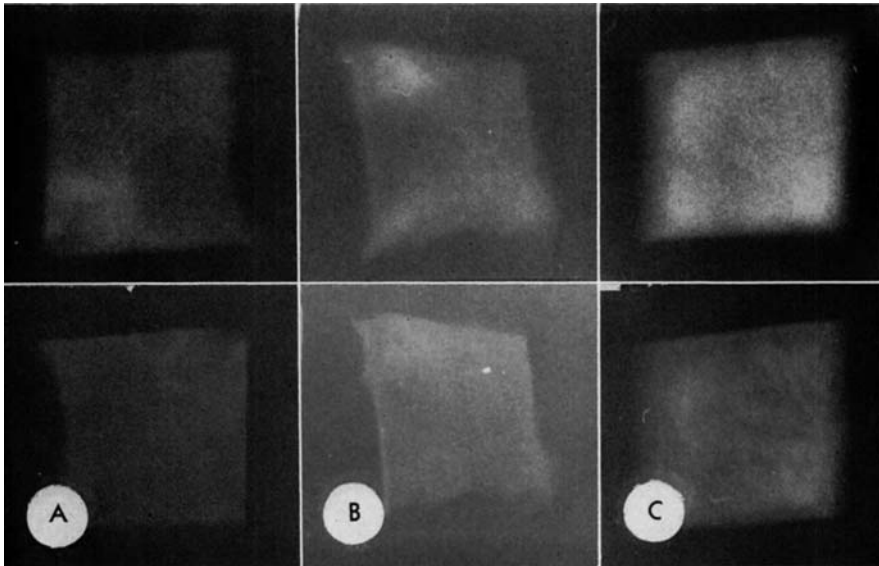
Neutron radiography of plant tissues demonstrates the sensitivity of neutrons to hydrogenous materials [3]
